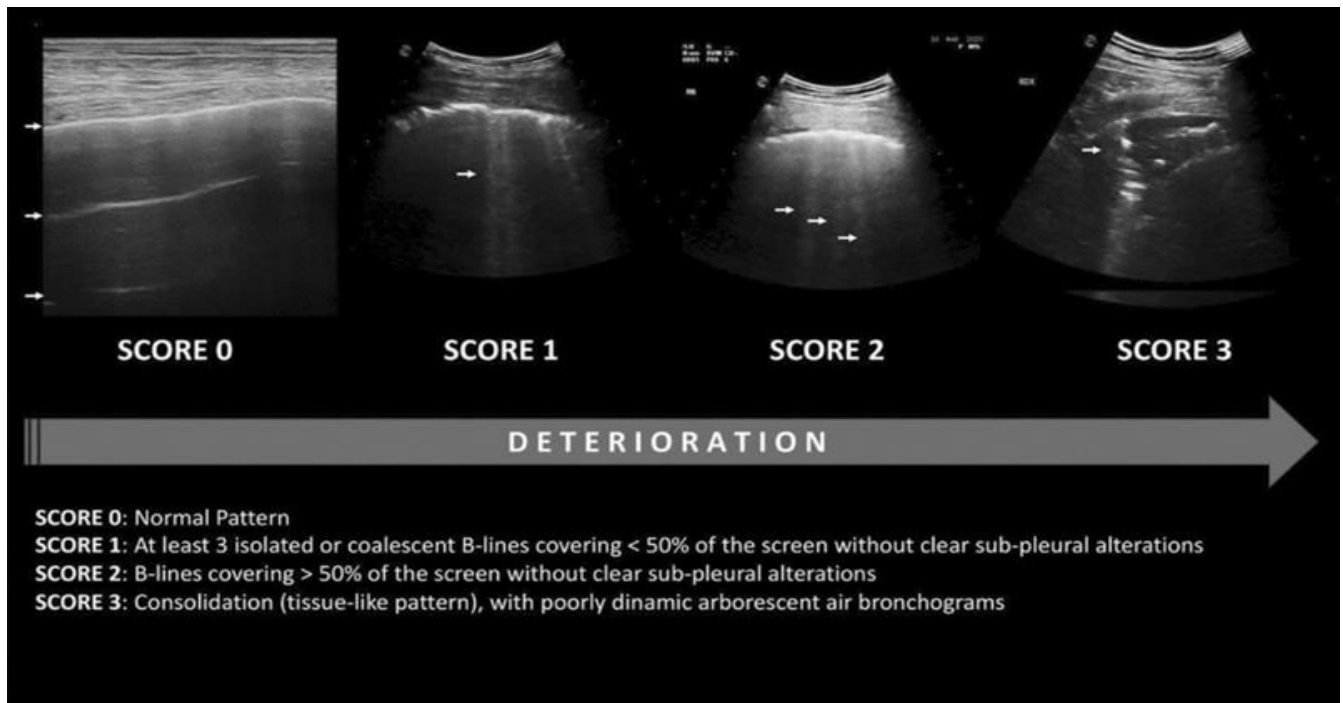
lung ultrasound score [13].
